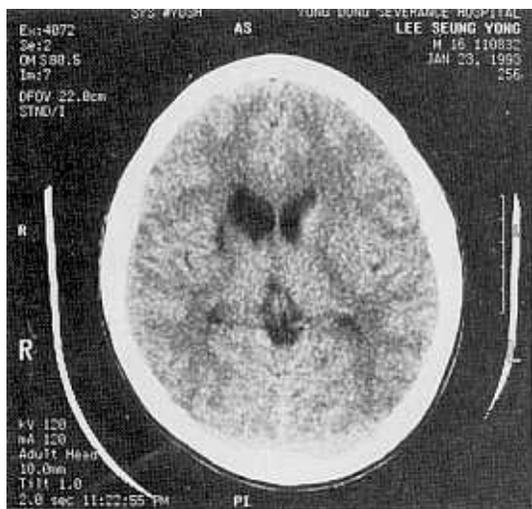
A brain CT scan of patient 3 revealed an area of low attenuation adjacent to the right internal capsule in the caudate nucleus with an enlarged right frontal horn.
